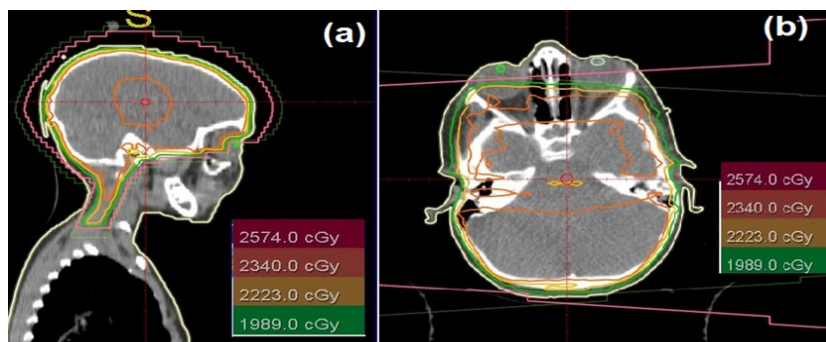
Isodose distributions for brain fields in the sagittal (a) and axial CT slices (b).
